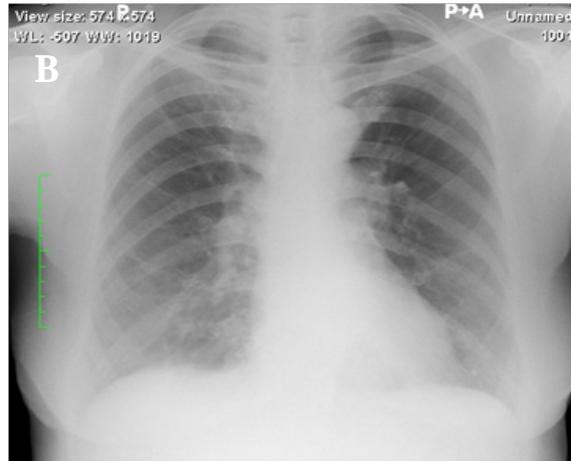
Chest X-ray examination for patient 1 (A and B) and patient 2 (C and D), both on admission (A and C) and discharge (B and D).
